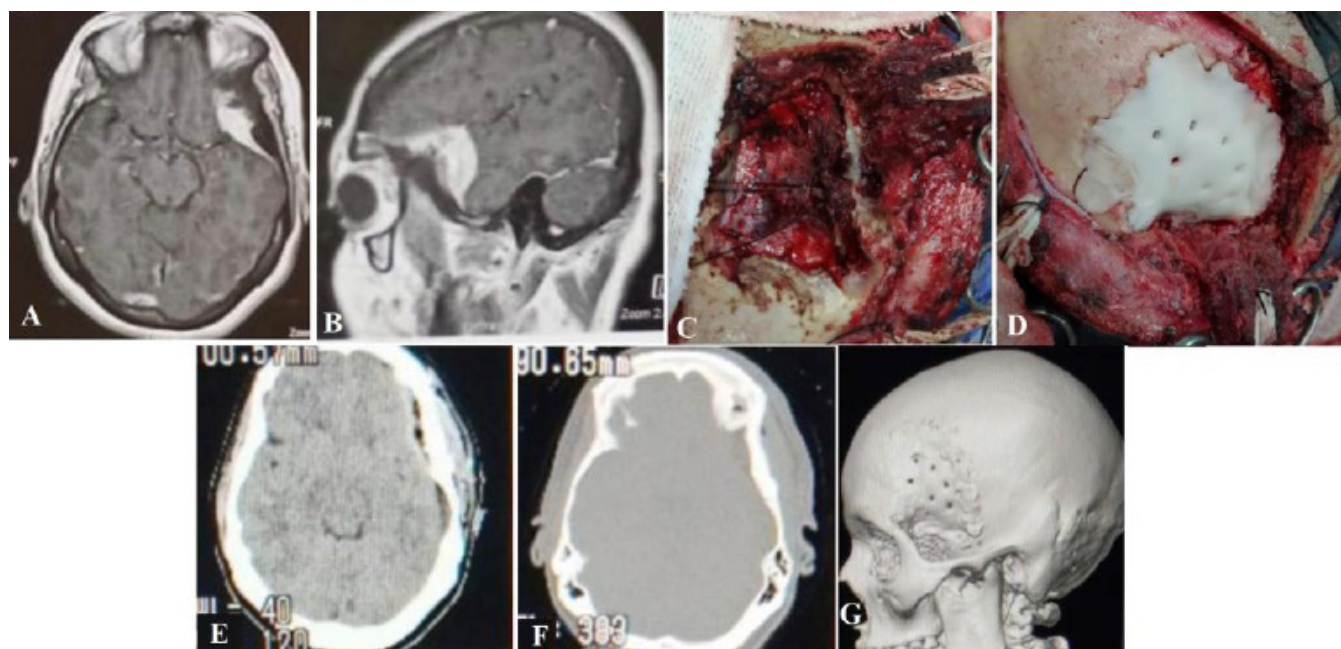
A) Axial MRI T1 WI with contrast showing left sphenoidal wing enhancing mass invading the bone giving en plaque view. B) Sagittal MRI T1 WI with contrast showing the same lesion. C) Intraoperative photo showing dissection and removal of the lesion with the overlying pathological bone. D) Intraoperative photo showing well fitted bone cement "PMMA" at the defective bony area after removal of the lesion. E) Axial CT image "soft tissue window" showing removal of the lesion with well positioned bone cement flap over the site of the lesion. F) Axial CT image "bone window" showing well positioned bone cement over of the site of the lesion after its removal. G) 3-D reconstructed CT image showing the final shape of the PMMA bone cement after its positioning over the site of excised lesion.
